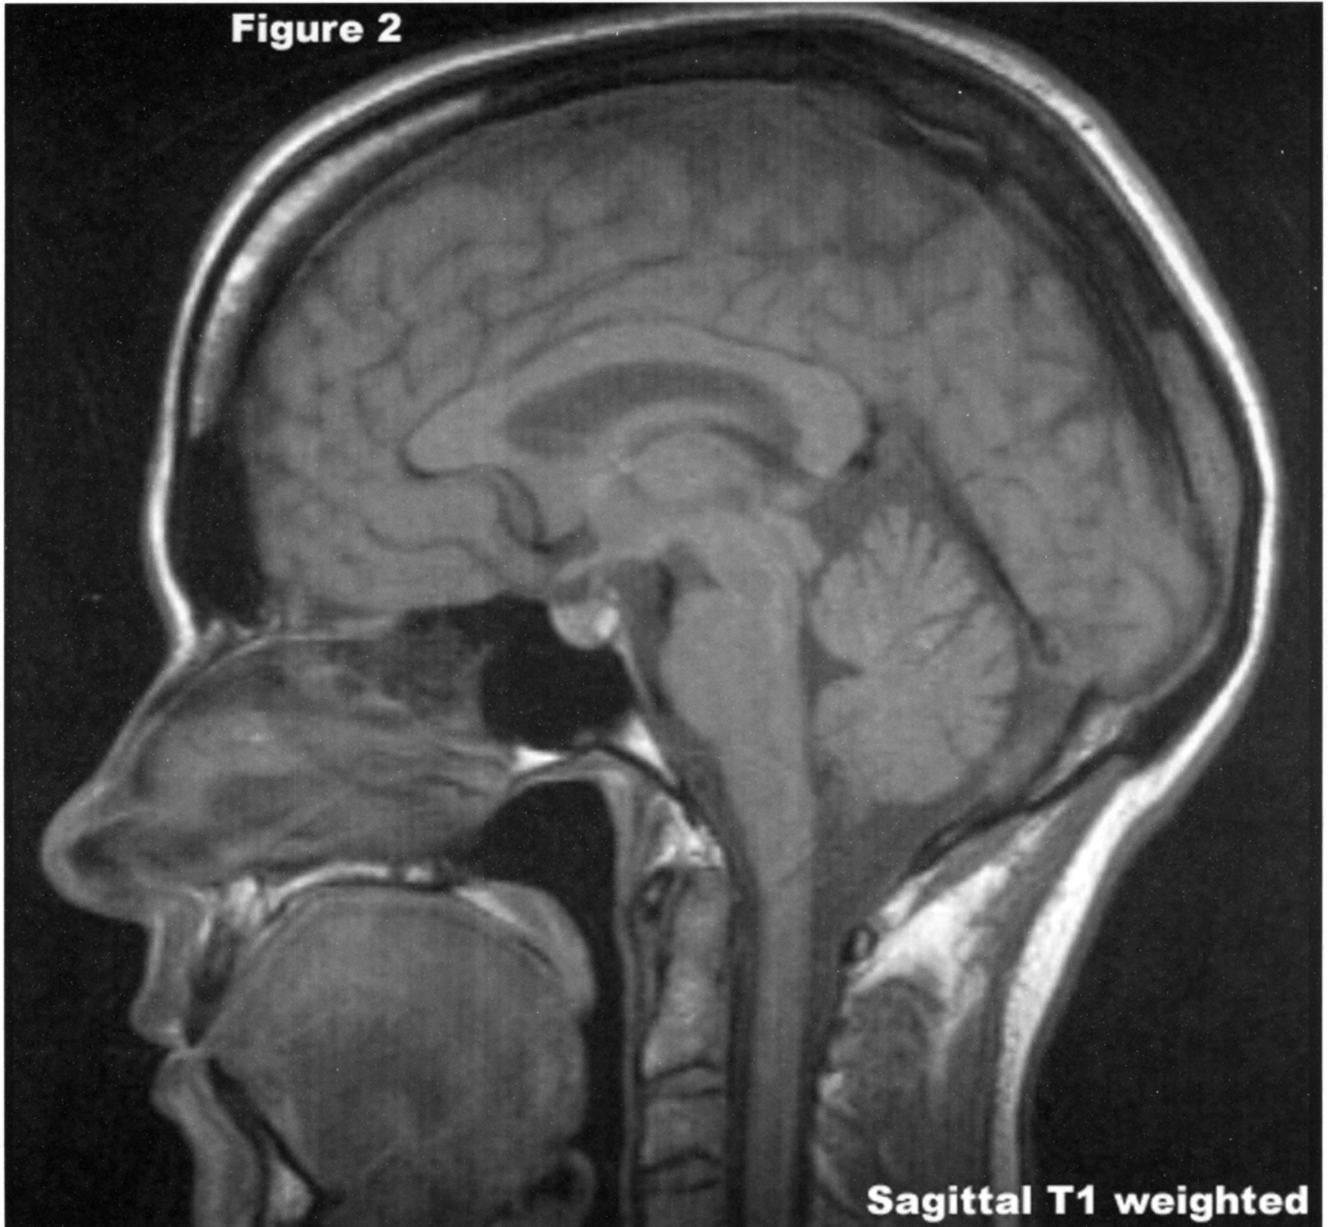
MRI of Normal Individual
